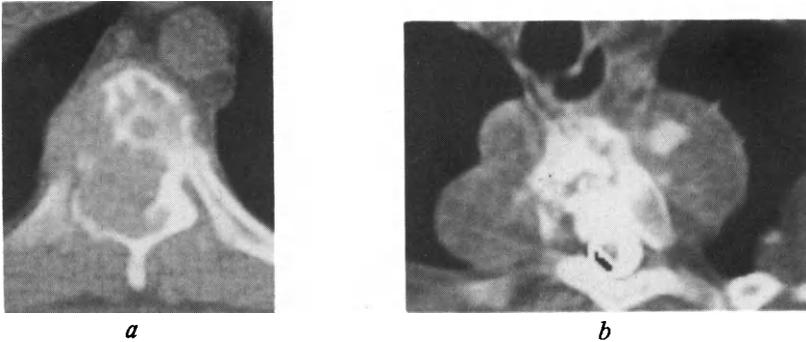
a, Myeloma: there is destruction of the right side and posterior half of the body and the right pedicle and also partial destruction of the right lamina of the sixth dorsal vertebra. The tumour causes a small right paravertebral mass and extends into the spinal canal but the theca and its contents are not visible separately from the tumour mass. *b*, Hydatid disease: CT section with intrathecal metrizamide. There are multiple paravertebral hydatid cysts. These are causing partial destruction of the body of the third dorsal vertebra, more extensive on the right side, and of the adjacent parts of the right ribs. There is angular kyphosis at the level of destruction which is causing the asymmetrical appearance of the metrizamide in the theca due to partial volume effect. The low density in the right side of the theca is an artefact due to computer overshoot associated with residual myodil from a previous study.
